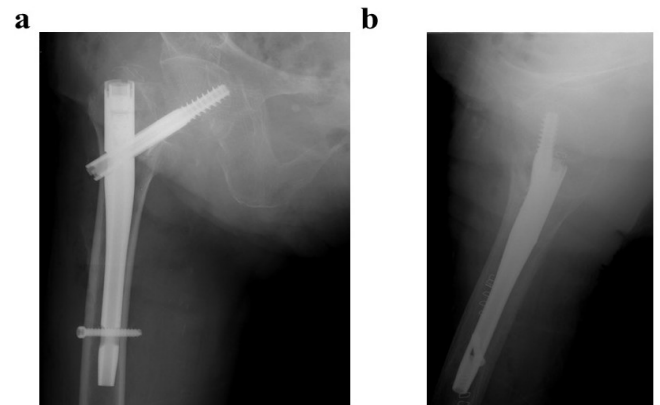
AP (a) and axial (b) radiographs of the right hip after the operation. Internal fixation was performed using a Gamma nail.
